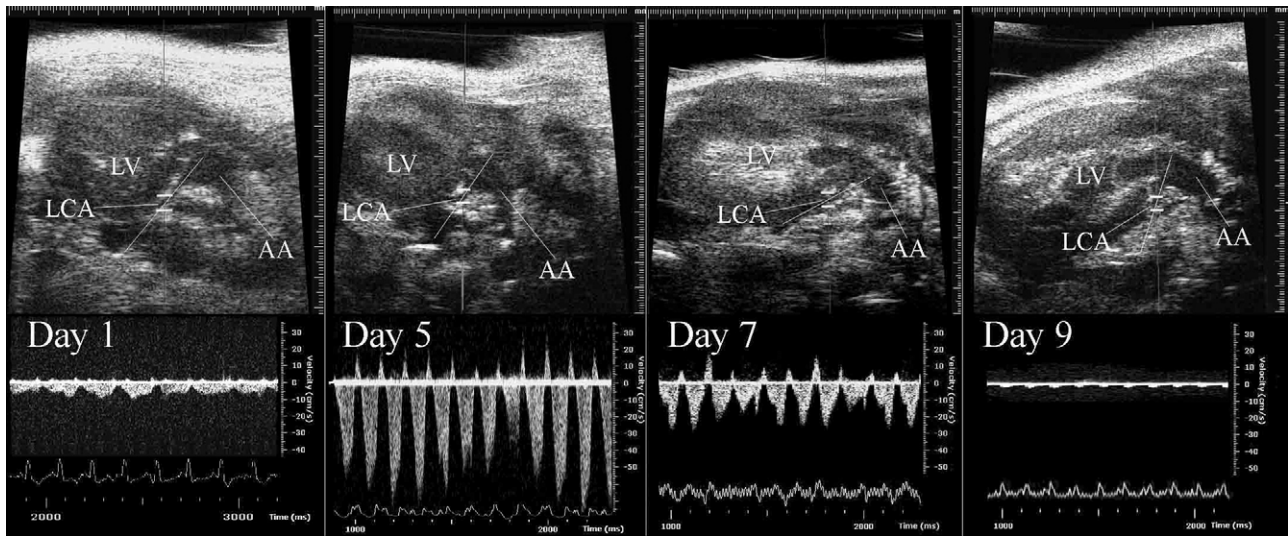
Doppler flow spectra of the left coronary artery (LCA) in an allograft on day 1, day 5, day 7 and day 9 posttransplantation. Note the modified imaging orientation and the consequent direction of the Doppler flow waveforms compared to Fig. 3. See previous figure legends for the definitions of other abbreviations.
